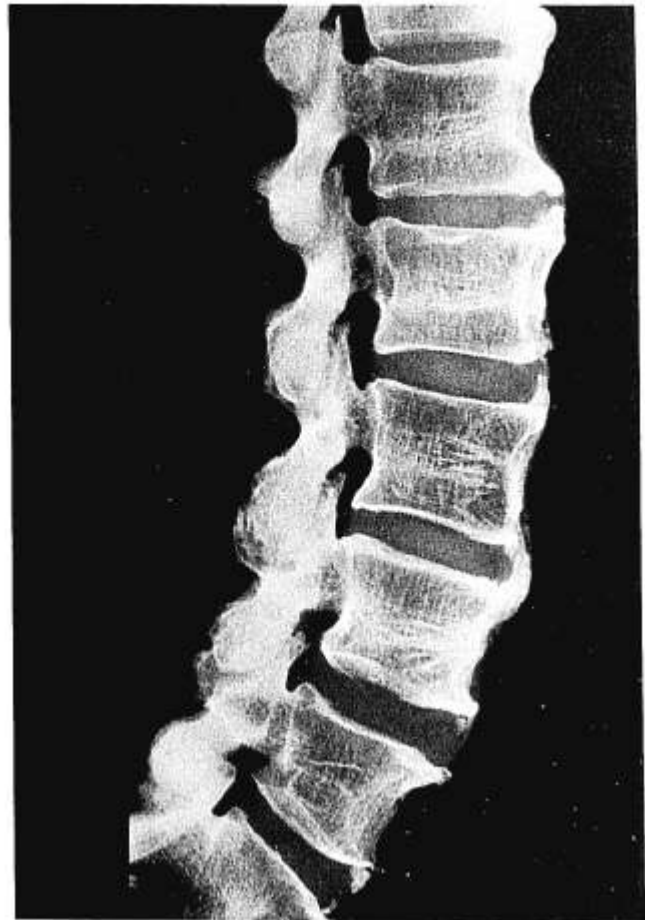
Fine-grain radiograph in the lateral projection of the lumbar spine in a 70-year-old man with Stage II Forestier's disease. Note the thickening along the anterior vertebral cortex and the characteristic vertical "flame-like" ossification of the anterior longitudinal ligament in front of the discs. Also note the normal disc height and absence of any significant degenerative process.
